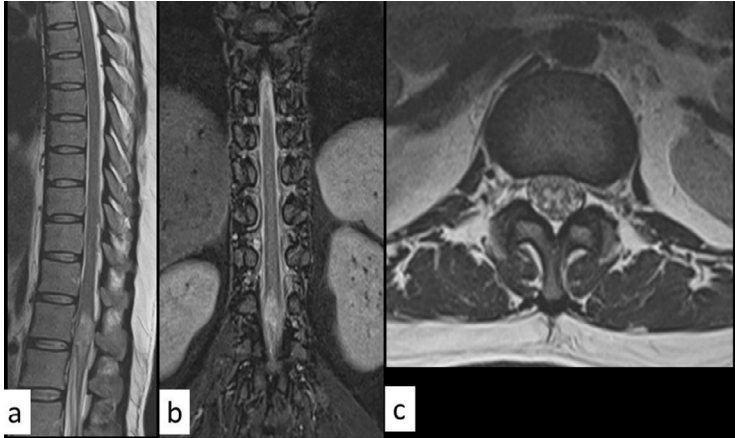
MRI of dorsal spine sagittal (a), coronal (b), and axial (c). T2WI shows focal cord expansion at the conus with increased cord signal intensity predominantly at the center.
